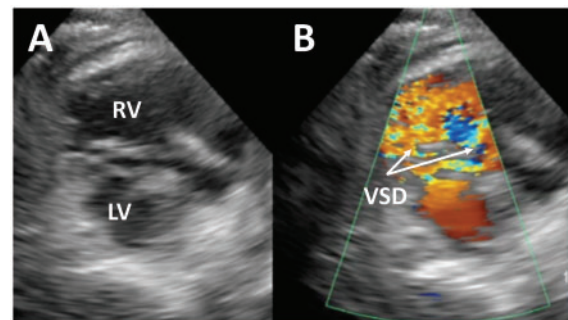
Transthoracic echocardiogram showed left-to-right shunt via ventricular septum defect opening near the base of the heart (A and B). LV, left ventricle; RV, right ventricle; VSD, ventricular septal defect.
